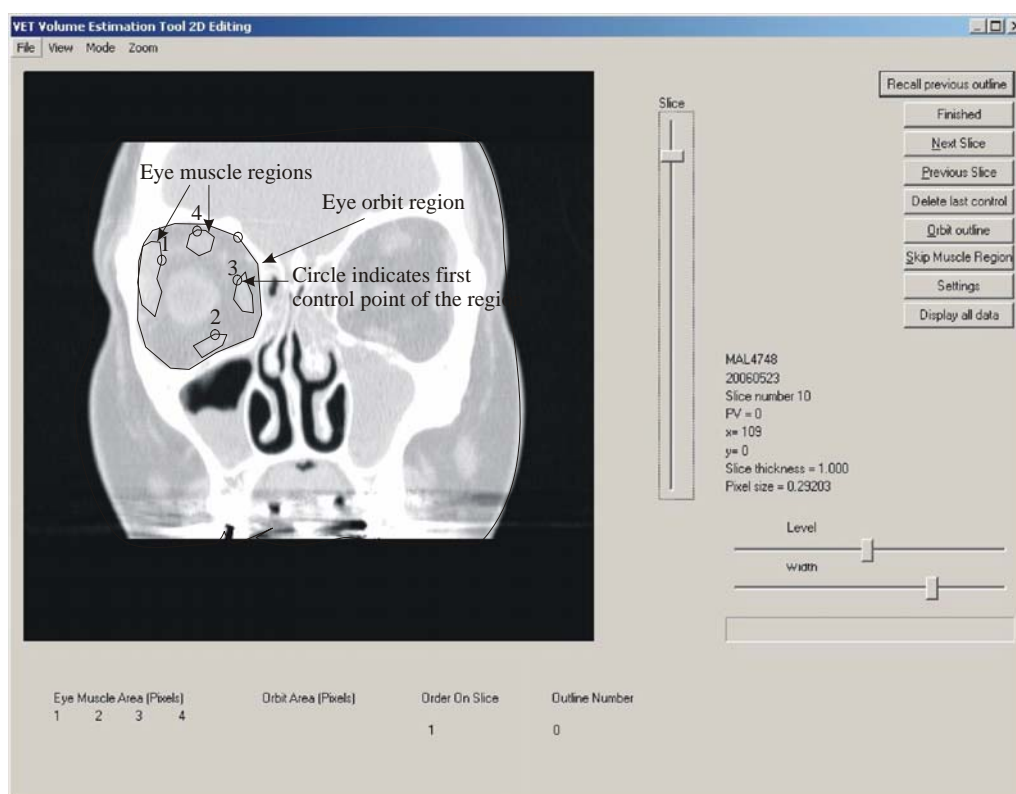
1 Image from the VET showing the coronal CT scan loaded and outlines of the 4 muscle regions and the orbit
